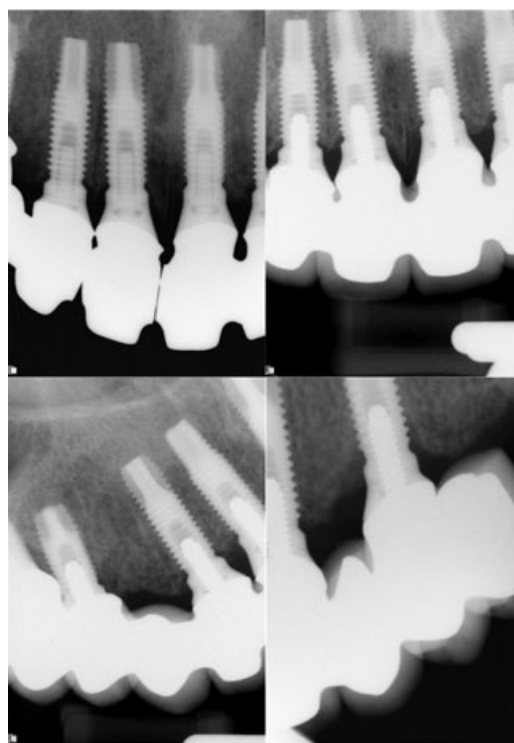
Postoperative radiographs 1 year after the prosthesis was placed. Note the level of the interproximal bone.
